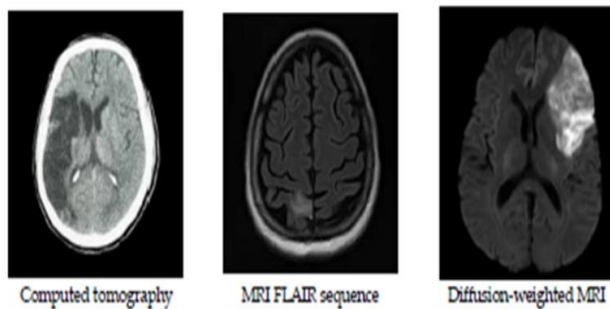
Sample of CT images, MRI Flair and DWI sequences images [10].
